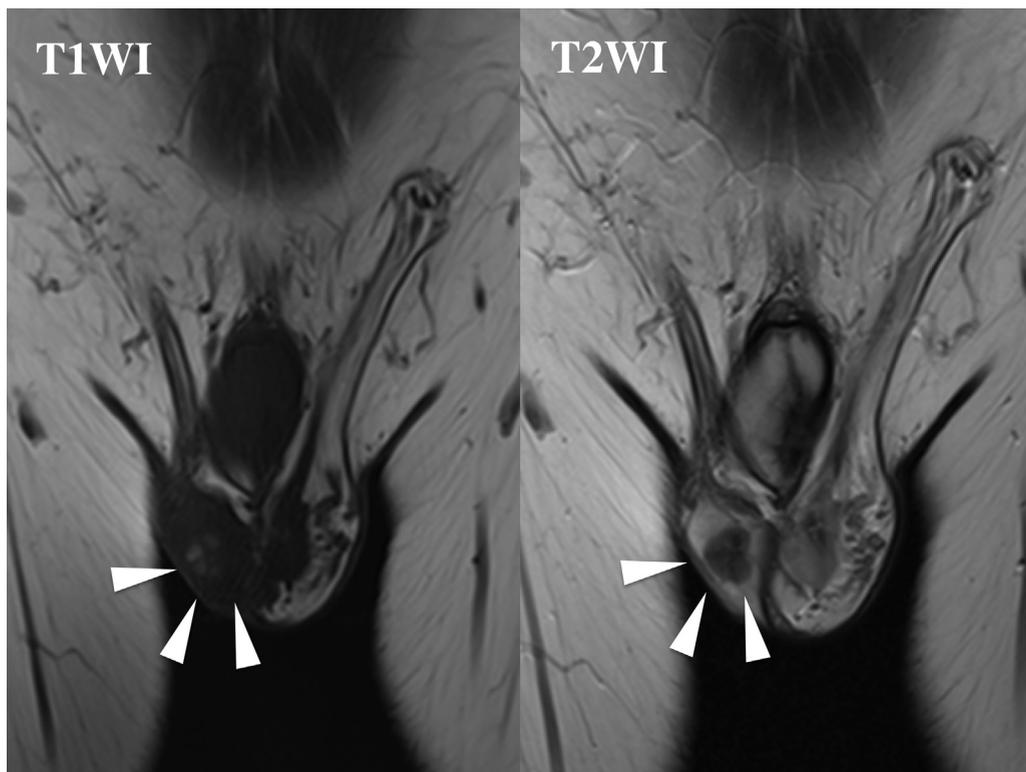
Magnetic resonance imaging findings. Images taken by T1WI (left) and T2WI (right). Arrows indicate the testicular tumor.
